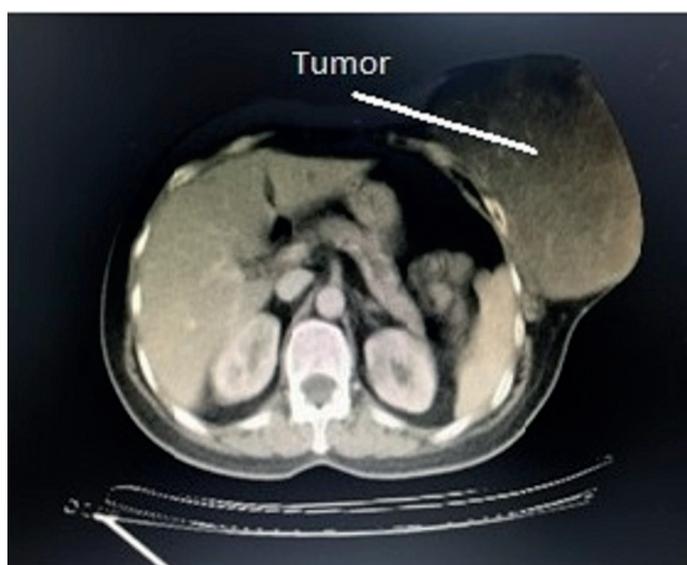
Axial CT image of DFSP in the left breast
